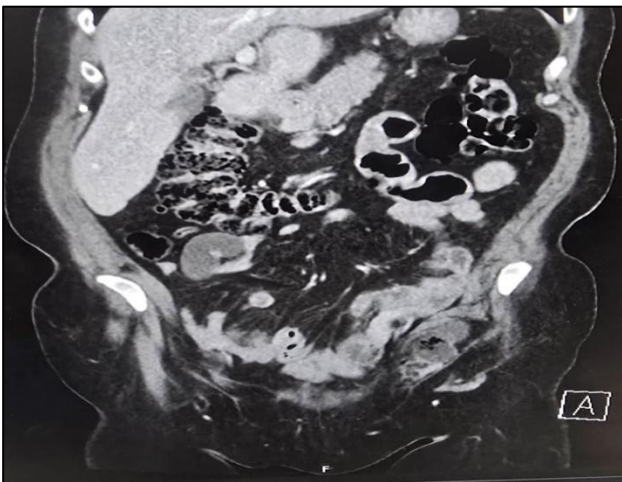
Coronal CT image of left sided Spigelian hernia containing incarcerated small bowel.
